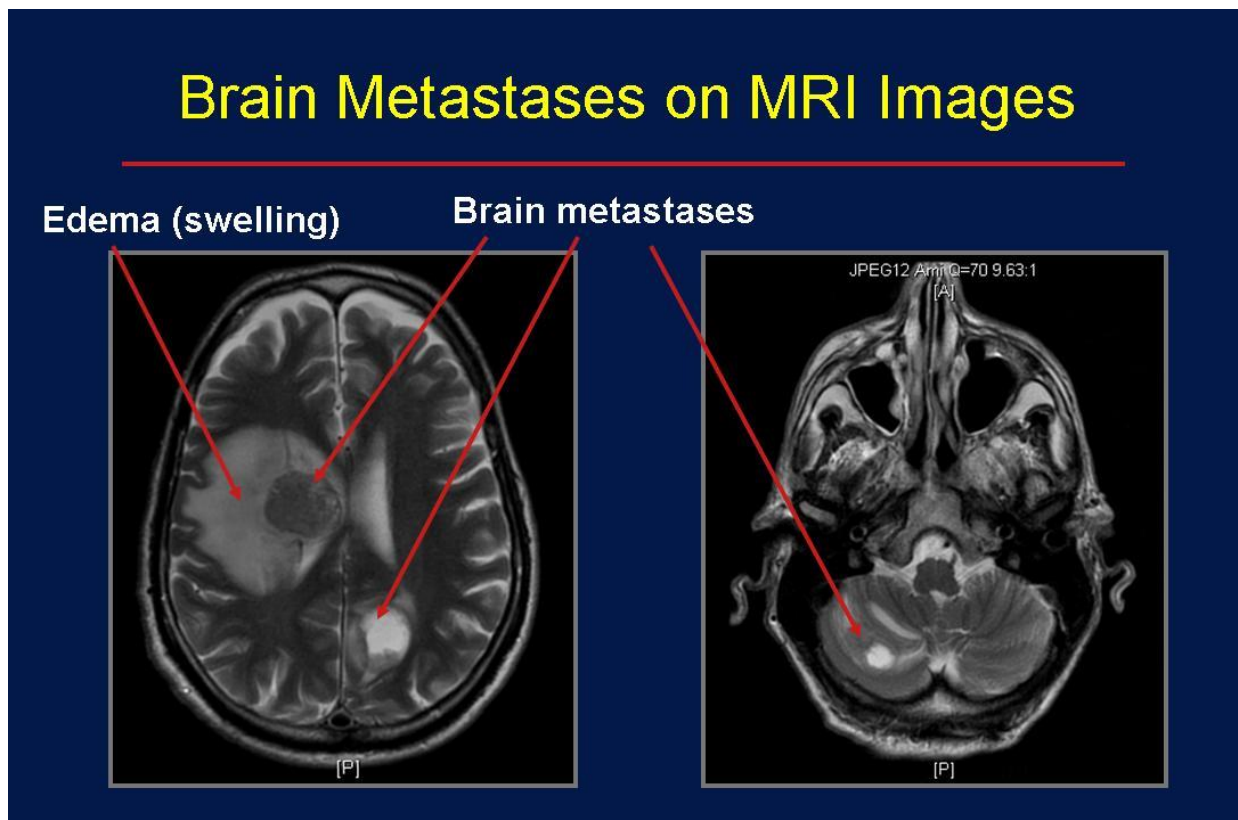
Magnetic resonance images of brain metastases.
